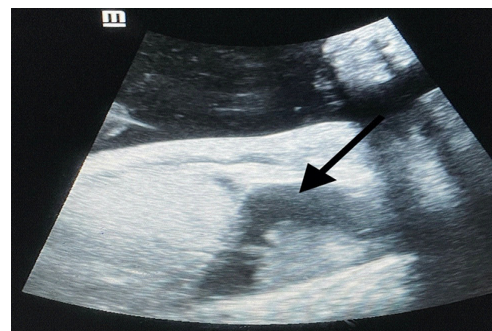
Ultrasound image of parasagittal fetal trunk showing fetal pleurisy (black arrow).
